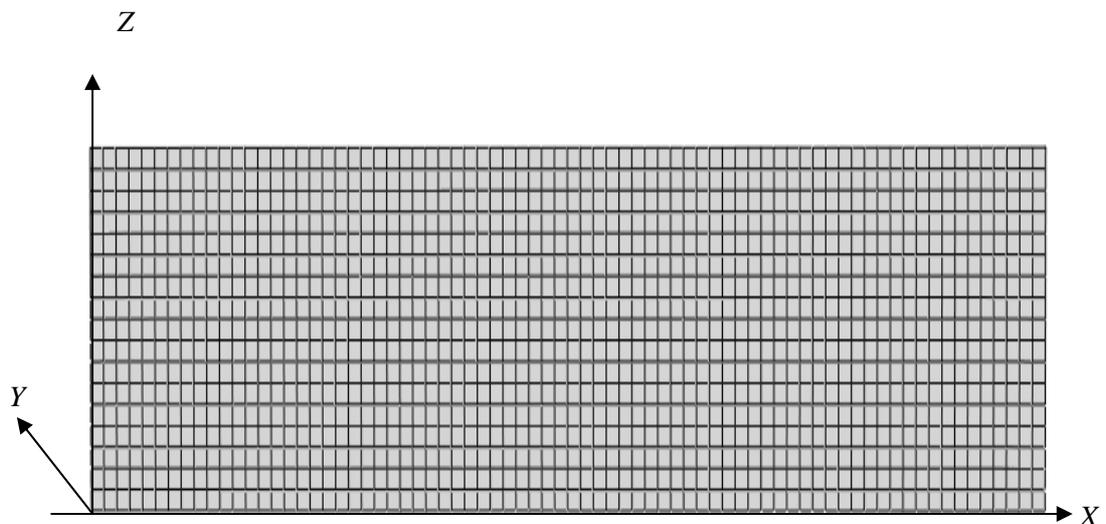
The structured pixel grid of diffusion tensor MRI (17 rows and 74 columns).
